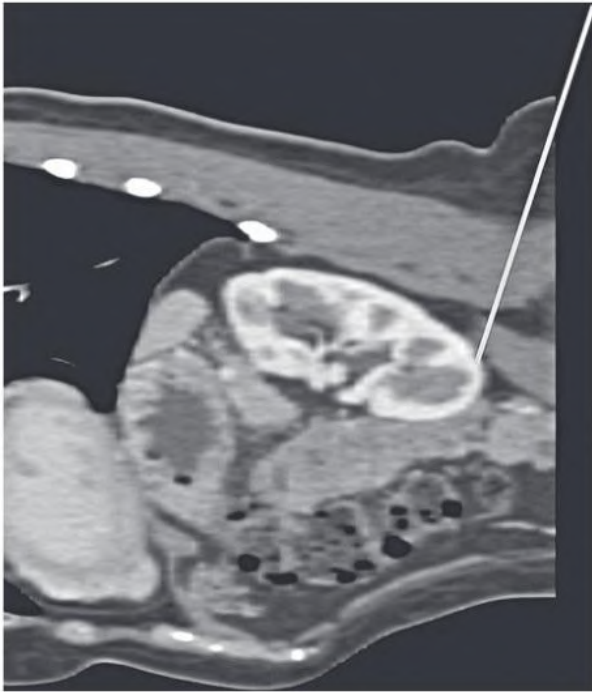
Computed Tomography Through the Left Kidney. The angle of approach of the needle is demonstrated. Note the relative adjacency of the lower pole of the kidney to other structures, particularly the large bowel.
